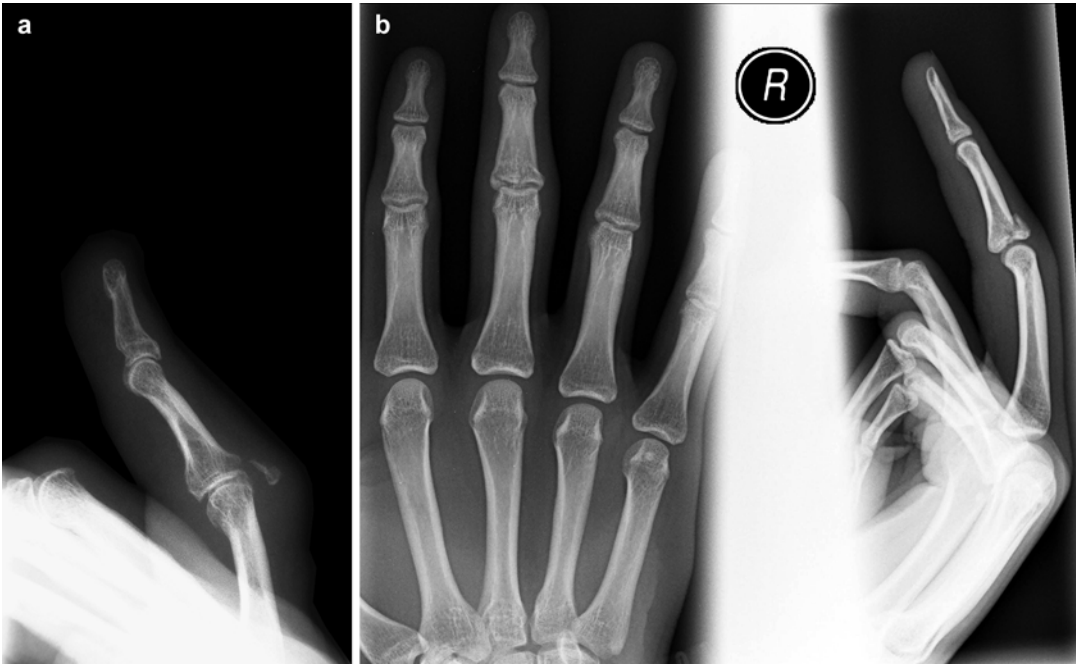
Radiographs of bony boutonniere injuries (a, b)
